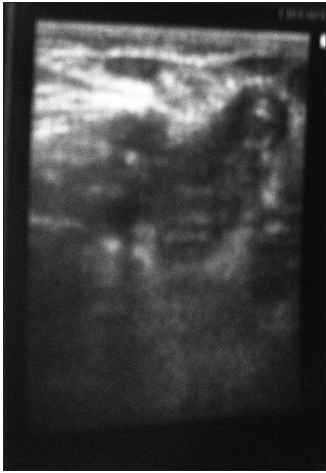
(Case 2) USG Doppler showing thrombus in Rt. Popliteal vein
